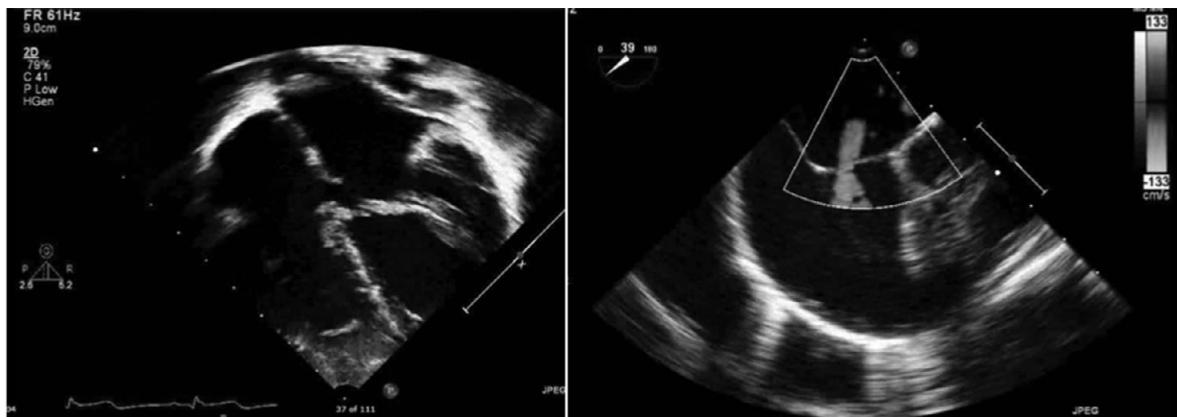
Transthoracic echocardiogram demonstrating a primum ASD (left) with large left to right shunting across the defect (right)
